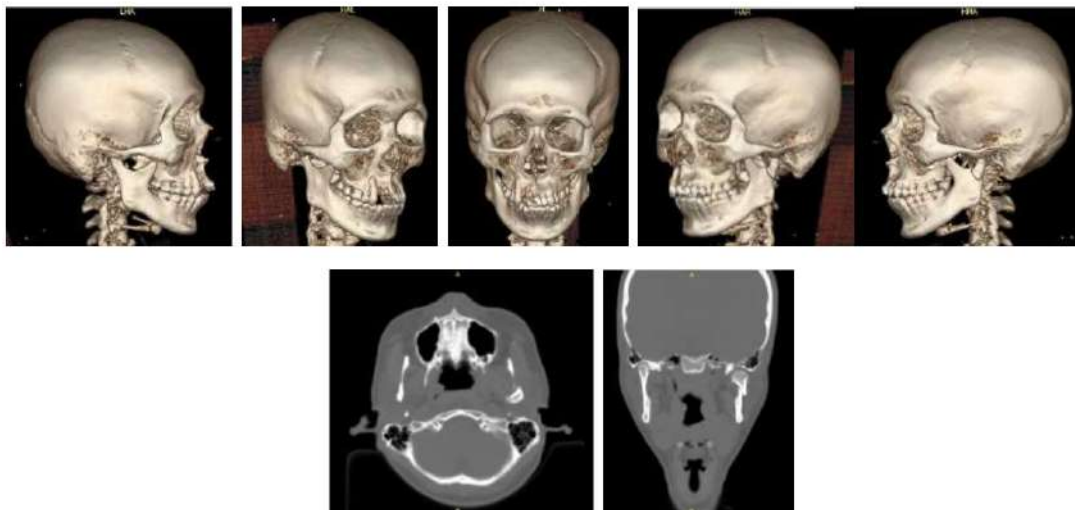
3D Head CT scan images show a fracture in the left mandibular sub-condyle without signs of bleeding, ischemic lesions, neoplasms, or other abnormalities
